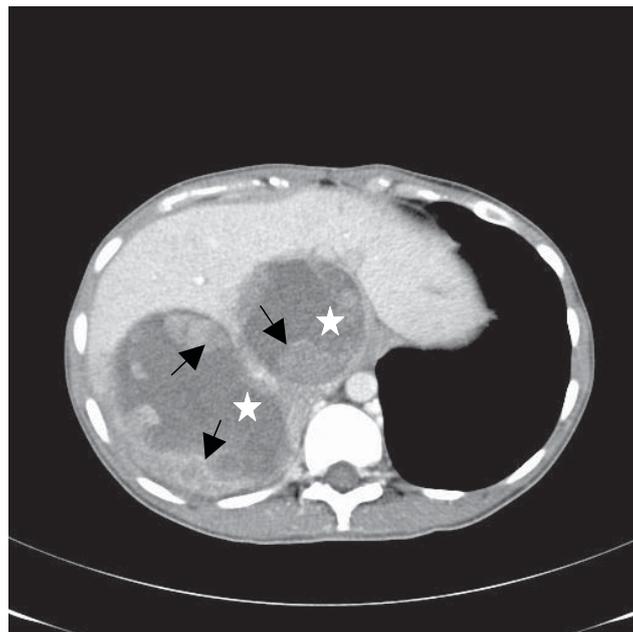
Axial image of contrast-enhanced CT demonstrating two of the liver metastases within segment VIII and segment IVa which contain necrotic/cystic areas (5-pointed star) and solid intraluminal projections (black arrows). The necrotic component increased with each RFA & TACE injections signifying partial success of treatment.
